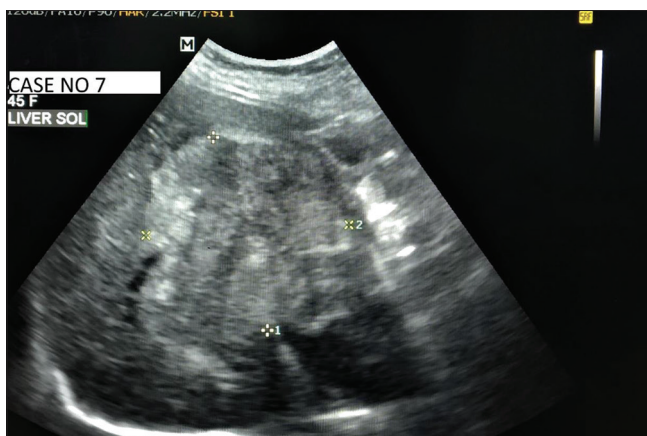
Ultrasonography: Mixed echogenic lesion with irregular border in the right lobe of liver : Primary malignant liver tumor
